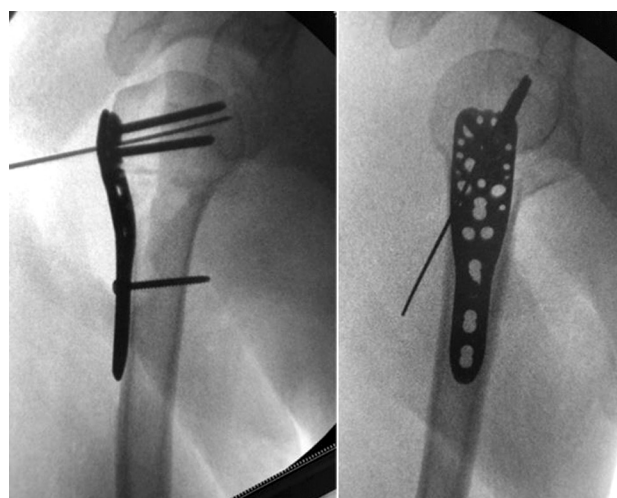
Radiographic control of fracture reduction with the plate
